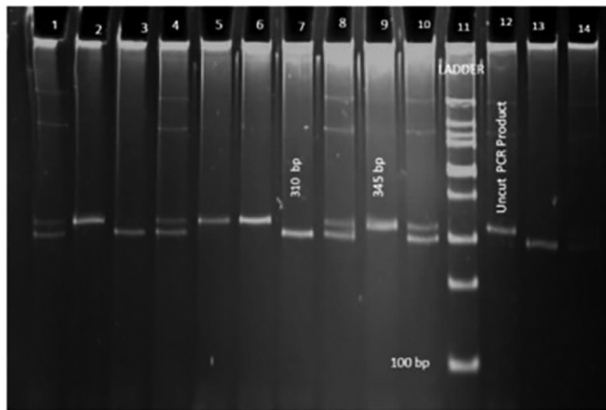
Gel image depicting the restriction fragments of the C69T single nucleotide polymorphism. Lanes 1, 4, 8, 10 and 14, CT; lanes 2, 5, 6 and 9, CC; lanes 3, 7 and 13, TT; lane 11, DNA ladder; lane 12, uncut PCR product.
